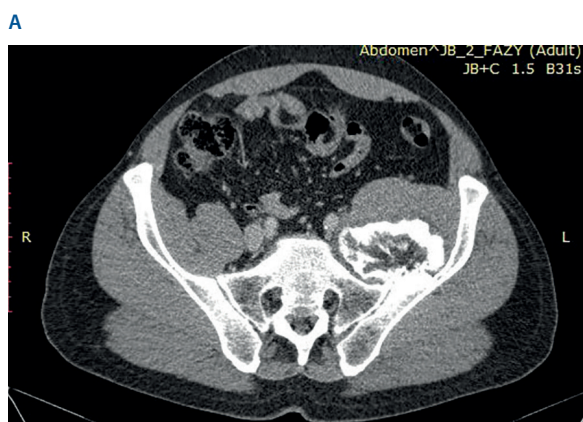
Male patient, aged: 41; chondrosarcoma of the iliac ala and left sacroiliac joint – CT image pre-op (A) and post-op (B)
